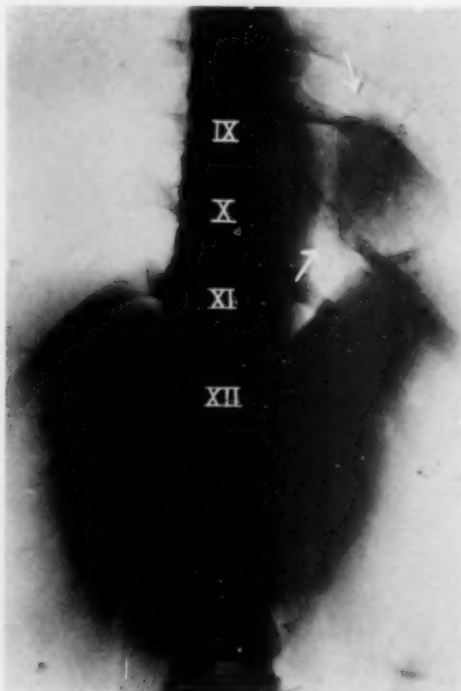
X-ray of Case VII, showing tumor opposite the ninth and tenth thoracic vertebrae.
